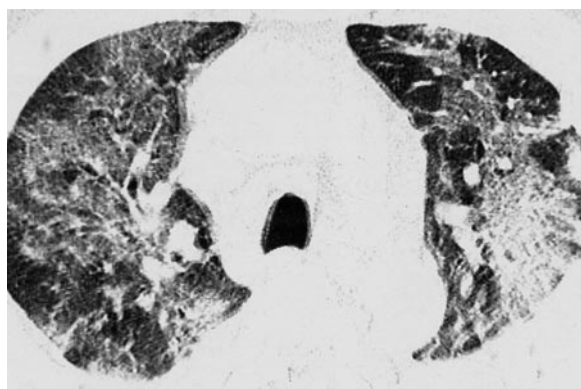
Ampicillin-induced pneumonia in a 69-year-old man with 24.1% peripheral eosinophilia. Transverse thin-section (1-mm collimation) CT scan (lung windowing) demonstrates multifocal patchy areas of ground-glass opacity with thickening of the interlobular and intralobular interstitium.
